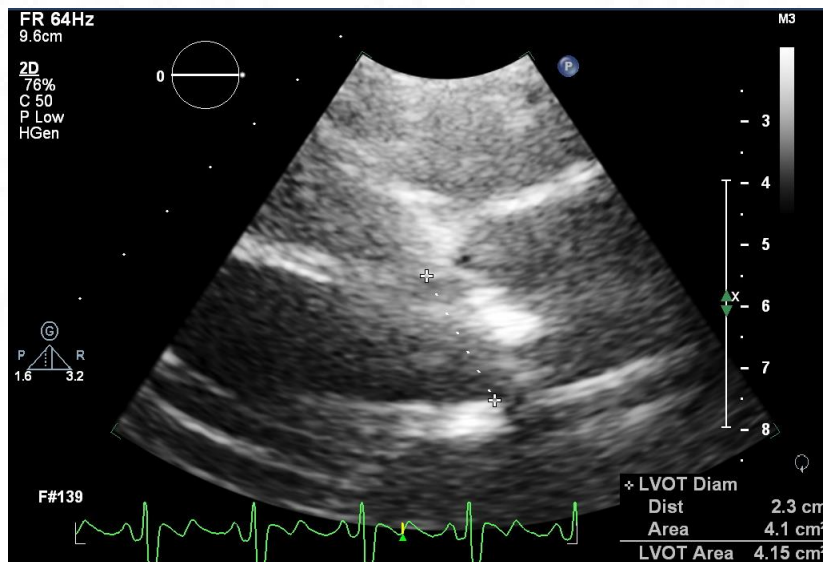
LVOT diameter calculation in parasternal LAX view
